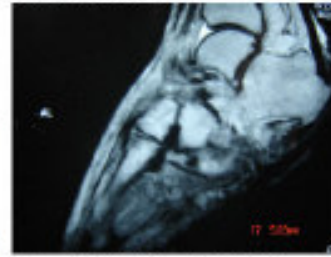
MRI, T2 W. image: Osteomyelitis of lateral part of the calcaneus.
